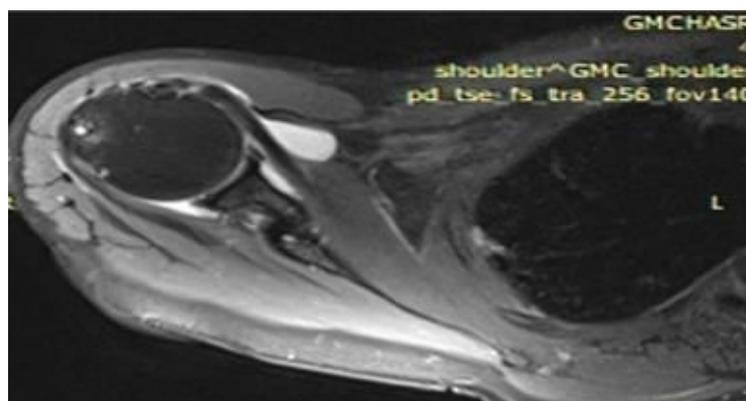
MRI T2W image of partial tear of subscapularis tendon
